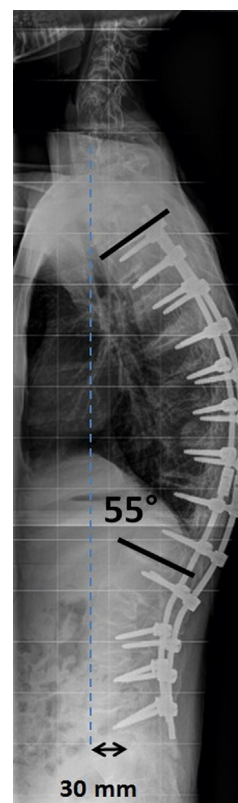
Postoperative sagittal radiograph showing good correction of kyphotic deformity and SVA.
